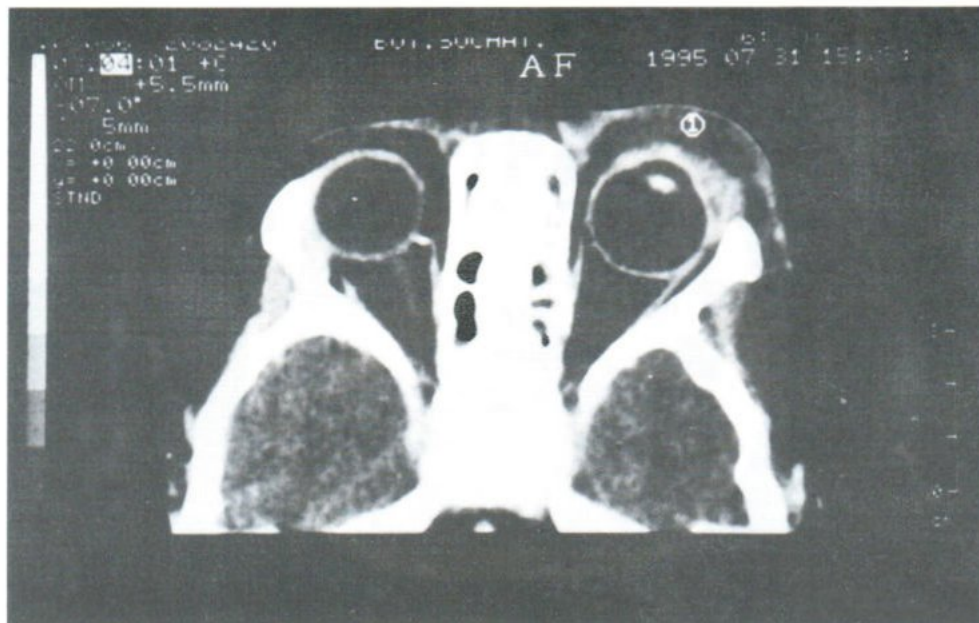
Preseptal Cellulitis: Axial CT scan shows diffuse soft tissue swelling involving the lid and conjunctiva anterior to the orbital septum.
